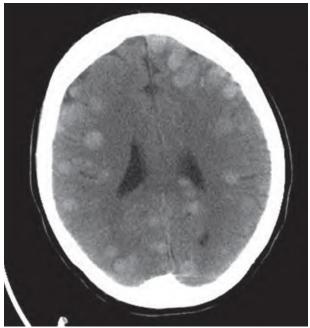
Computed tomography scan of a patient with tuberculous meningitis and numerous intracerebral granulomas.
